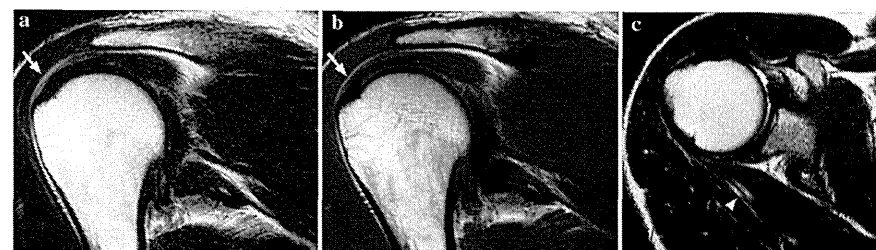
MR findings 3 months after the injury (a T2-weighted oblique coronal image; b T1-weighted oblique coronal image; c T2-weighted axial image). In the T2-weighted image, the subacromial bursa was depicted with high intensity (a arrow). On the other hand, it was depicted with low intensity in the T1-weighted image (b arrow). The
